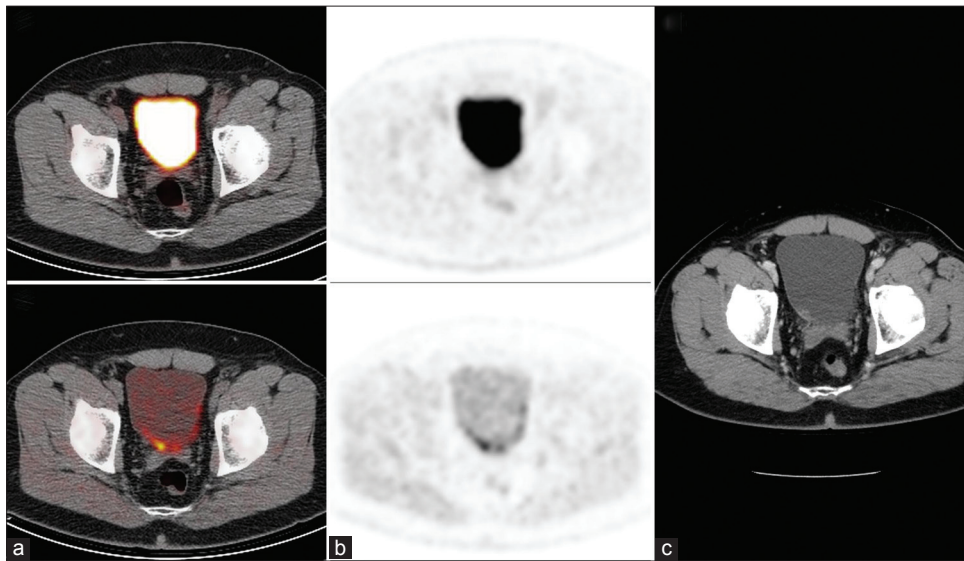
An 83-year-old male with a solitary cT2N0M0 G3 UCC of the bladder. <sup>18</sup>F-2-fluoro-2-deoxy-D-glucose-positron emission tomography combined with computed tomography (FDG-PET/CT) and FDG-PET (from left to right) images before furosemide, (a) show high FDG activity in the bladder standardized uptake values (SUV<sub>max</sub> = 22.2). Delayed pelvic images after intravenous furosemide and oral hydration, (b) show good tracer washout in the bladder (SUV<sub>max</sub> = 5.0). It is clearly possible to identify uptake in the right bladder wall, which can be delineated with 50% isocontour (SUV<sub>max</sub> = 16.1). CE-CT (c) showed focal wall thickening, corresponding to the intense uptake area on FDG-PET/CT. The tumor was also visualized by routine cystoscopy. The patient was treated with brachytherapy preceded by external radiotherapy because of a solitary cT2N0M0 G3 UCC of the bladder
